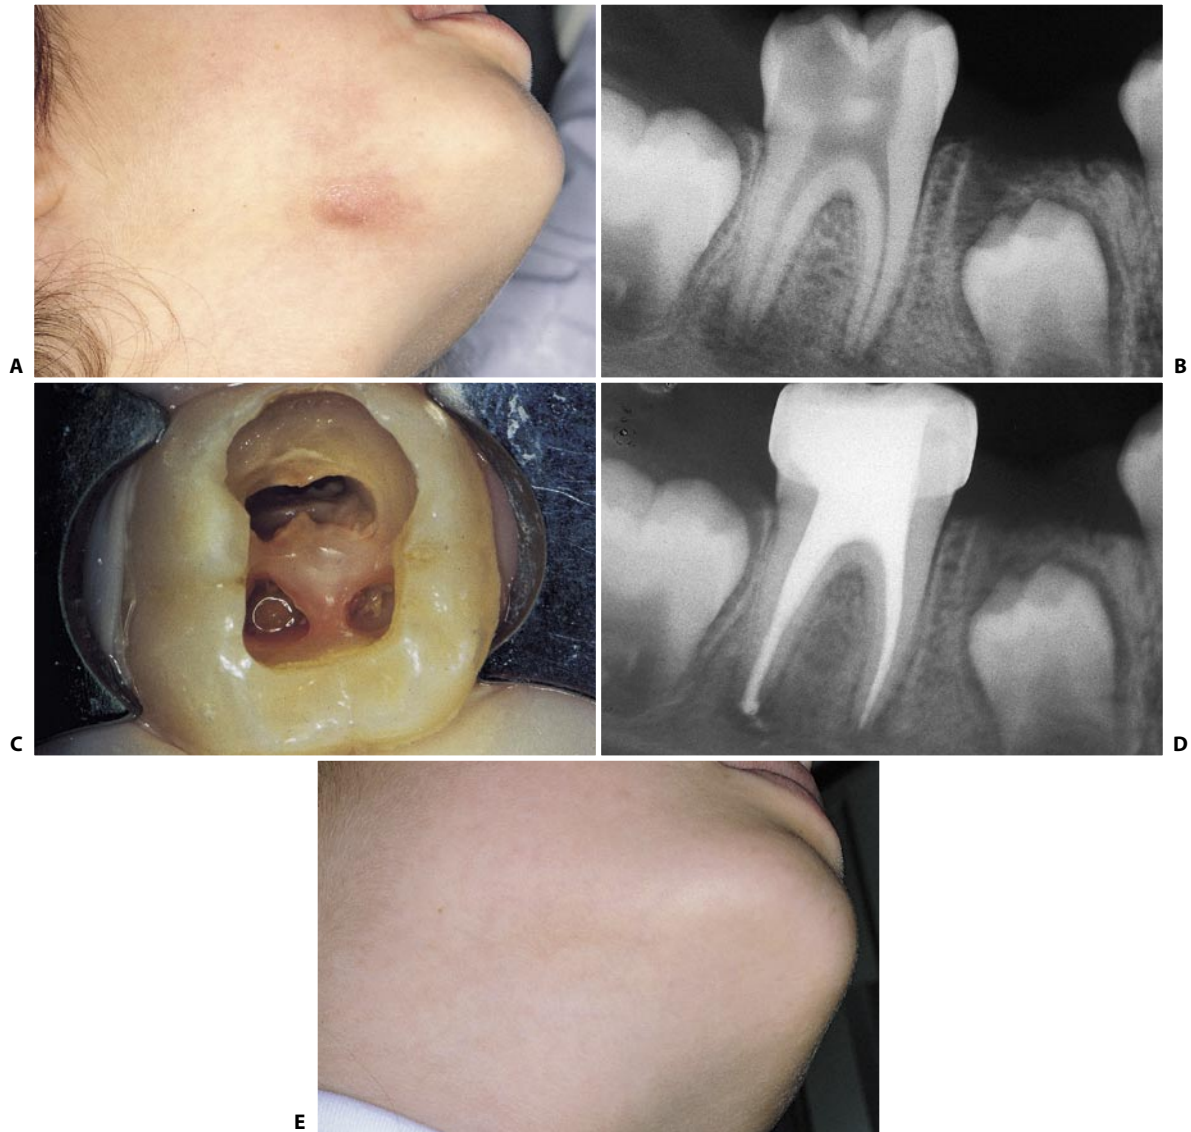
A. Cutaneous fistula in the right submandibular region. B. Preoperative radiograph of the ipsilateral lower first molar. The tooth had been “opened” one month before and left open “to drain.” Note the small radiopacity at the center of the access cavity, due to a residuum of the chamber roof left in place. C. Clinical appearance of the access cavity: three openings have been made in the roof of the pulp chamber! One, corresponding to the distal canal, is shaped like an “8”; the two round ones correspond to the mesial canals: the pulp horns have been misdiagnosed for canal orifices. D. Postoperative radiograph. The tooth has been pretreated with a cooper band. E. Healing of the fistulous tract two years later. Note the complete absence of any scarring.
